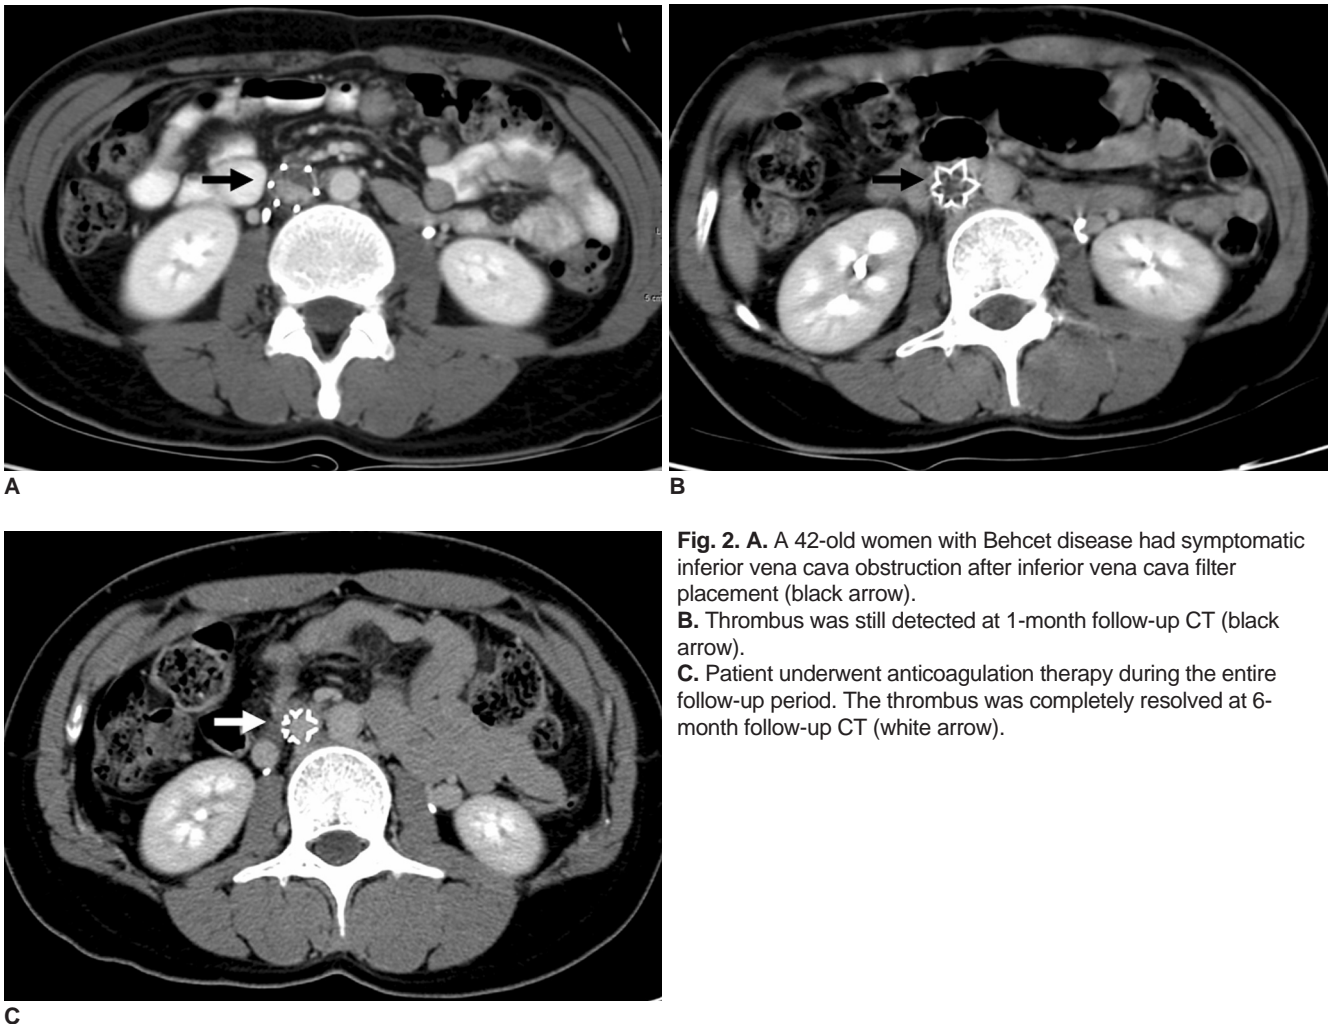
A. A 42-old women with Behcet disease had symptomatic inferior vena cava obstruction after inferior vena cava filter placement (black arrow). B. Thrombus was still detected at 1-month follow-up CT (black arrow). C. Patient underwent anticoagulation therapy during the entire follow-up period. The thrombus was completely resolved at 6-month follow-up CT (white arrow).
